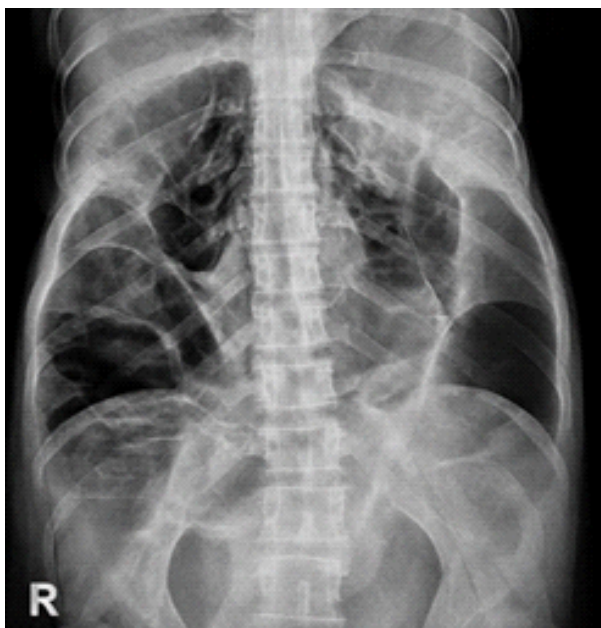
Abdominal X-ray showing dilated large bowel loop consistent with acute colonic pseudo-obstruction.
